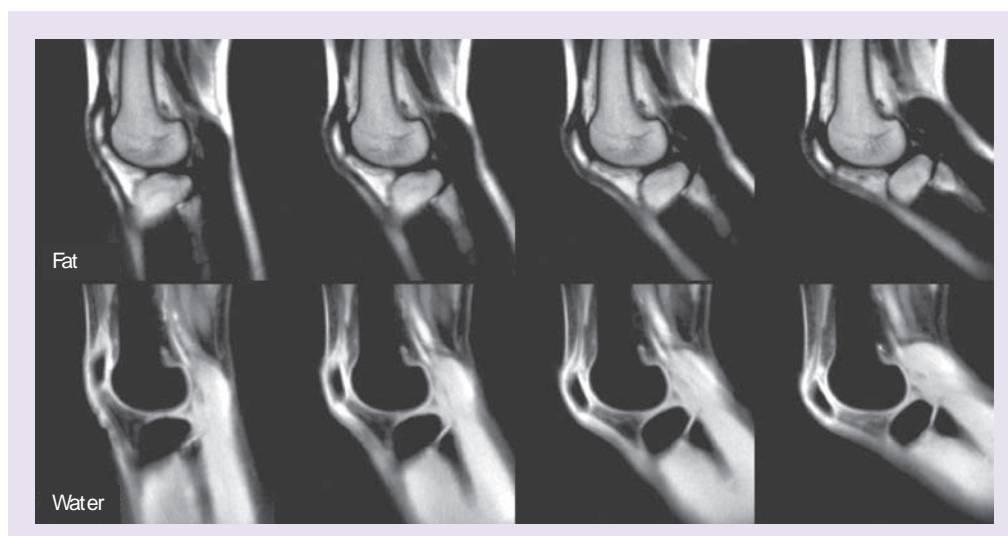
Real-time MRI of knee movements with separation of (top) fat and (bottom) water components. Selected frames obtained every 4 s from a respective movie at 250 ms temporal resolution (4 fps) acquired using triple-echo radial fast low-angle shot (45 spokes, repetition time/echo time = 5.50/1.78–3.16–4.54 ms, flip angle 12°, 1.0 × 1.0 × 5.0 mm³). For further details see the 'Water–fat separation' section.
